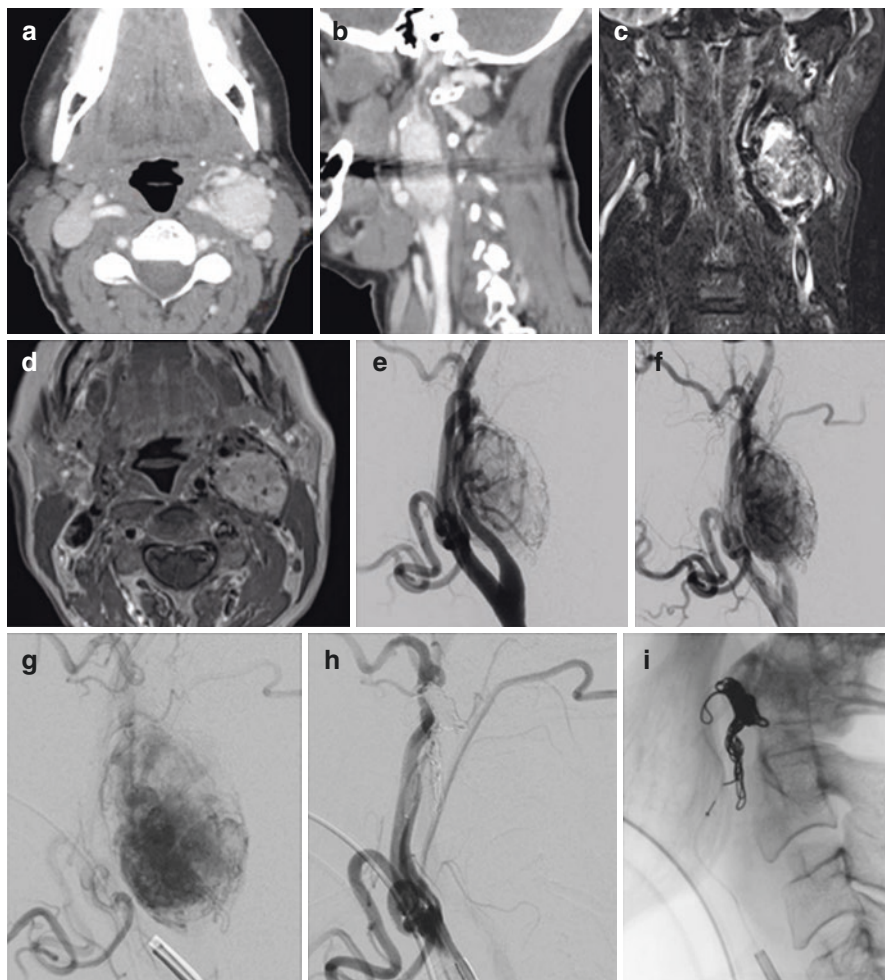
Glomus vagale tumor is a less common type of glomus tumor, but is often confused for a glomus caroticum. Contrast enhanced axial (a) and sagittal (b) CT views demonstrate an avidly enhancing tumor within the carotid sheath, slightly above the bifurcation. Internal carotid and external carotid arteries are not splayed but displaced anteriomedially. Coronal STIR (c) and axial post contrast T1 weighted (d) images demonstrate a T2 hyperintense enhancing (isointense on pre contrast T1 sequences) mass of the carotid sheath. Dark flow voids against the background of a T1 hyperintense tumor demonstrate the classic “salt and pepper” appearance of a glomus tumor. Left common carotid digital subtraction angiography demonstrates an avidly enhancing mass in the early arterial (e), late arterial (f), and capillary (g) phase *above* the carotid bifurcation. Subtracted (h) and unsubtracted (i) post 100–300 micrometers embospheres and coil embolization of the ascending pharyngeal artery angiography demonstrates complete devascularization of the tumor. Estimated operative blood loss was 50 cc
